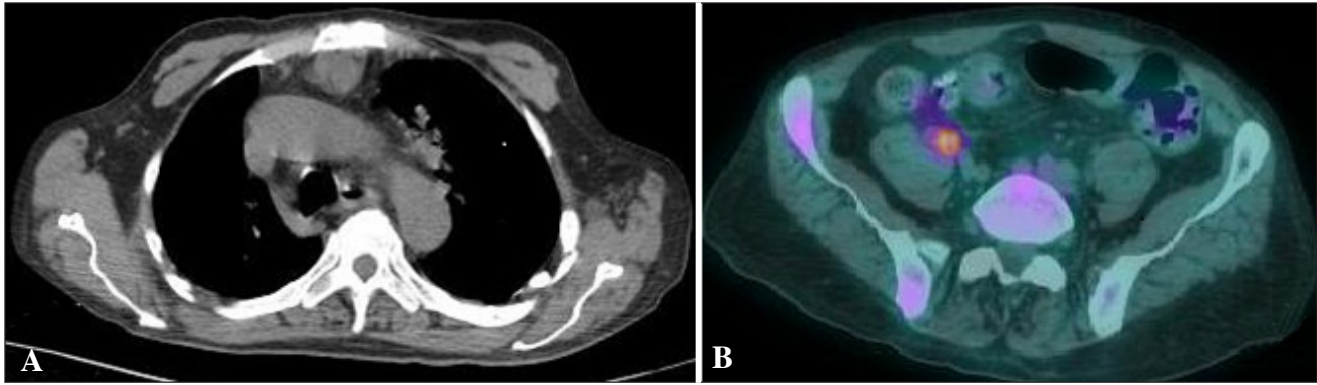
Postoperative computed tomography (CT) of the chest (A) and positron emission tomography – computed tomography (PET-CT) scans of the chest, abdomen and pelvis
